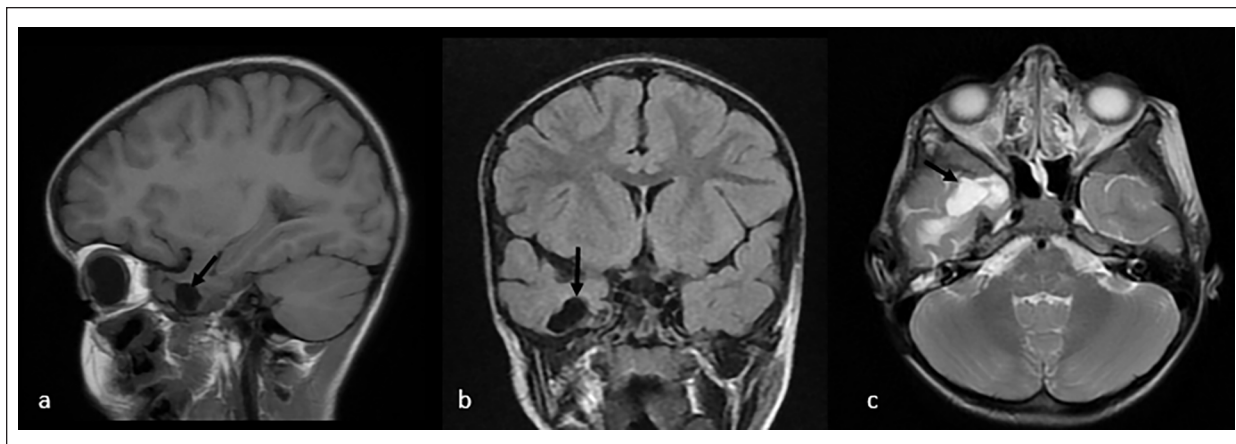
Follow up MR images: sagittal T1 sequence (a), coronal FLAIR sequence (b) and axial T2 sequence (c) showing a small residual cavity in the right temporal area (black arrows) with no remaining tumor residue.
